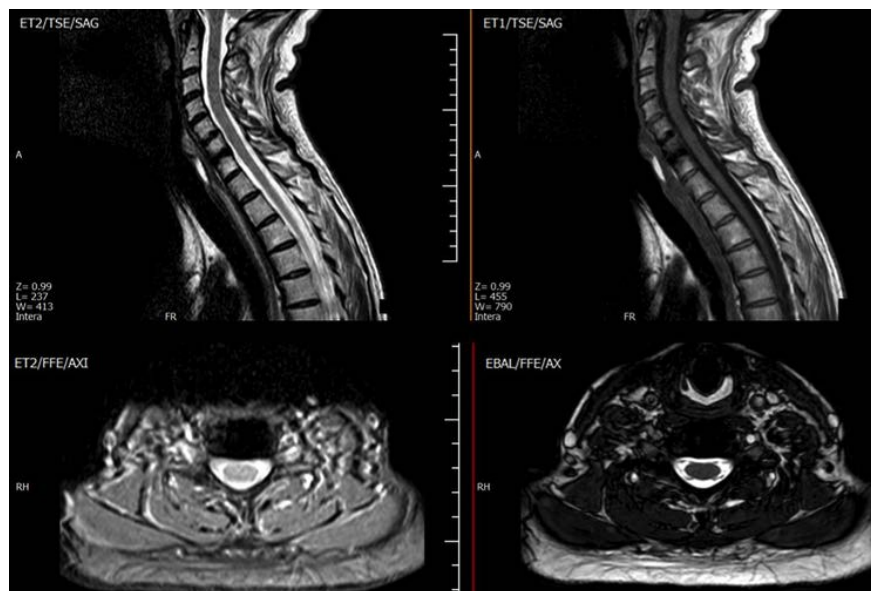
MRI Images of a spine that contains the TTN-coated cage investigated in this study. The images demonstrate an excellent visualization of disc, foramina and canal, avoiding postoperative MRI artifacts.
